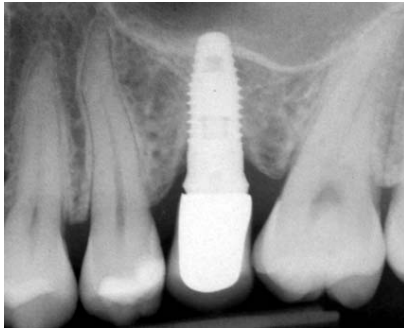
Periapical radiograph showing incomplete seating of this premolar crown on the implant abutment on this implant in the 25 position.
